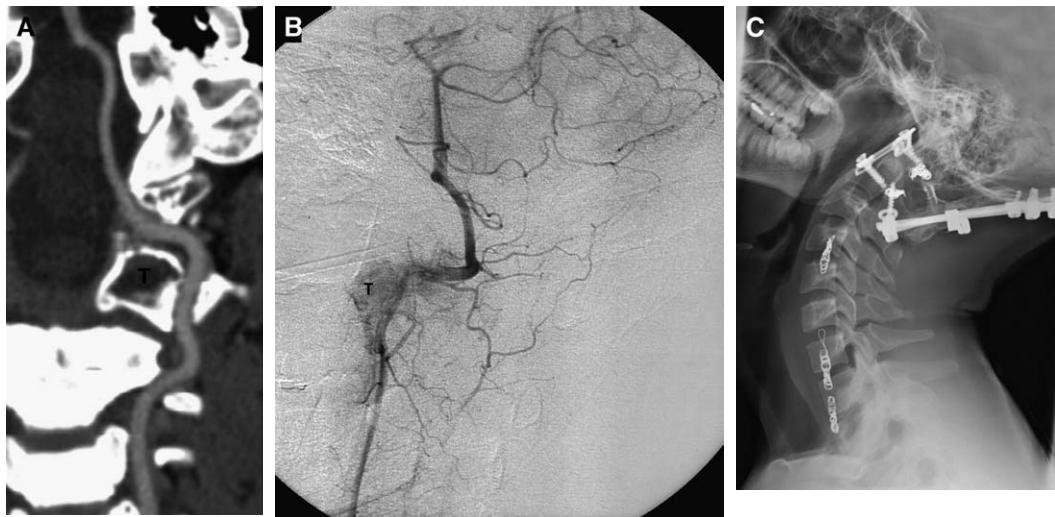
(A–C) CTA shows patent vertebral artery encased by osseous C₂ tumor (T). Vertebral angiogram reveals a hypervascular mass. Preoperative vertebral artery sacrifice using platinum microcoils was performed in this adolescent with C1 osteoblastoma.
